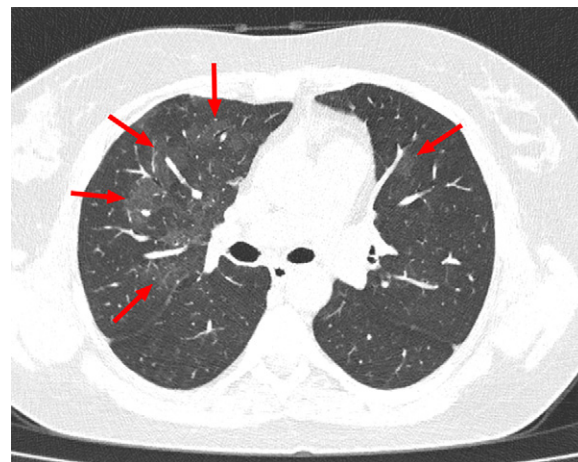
Example of indeterminate CT imaging features for COVID-19 in a 36-year-old female patient. Chest CT image shows bilateral multifocal ground-glass opacities (arrows), which were mainly located in the right upper lobe. There was no posterior part/lower lobe predilection, and there was also no peripheral/subpleural distribution of lung abnormalities.
